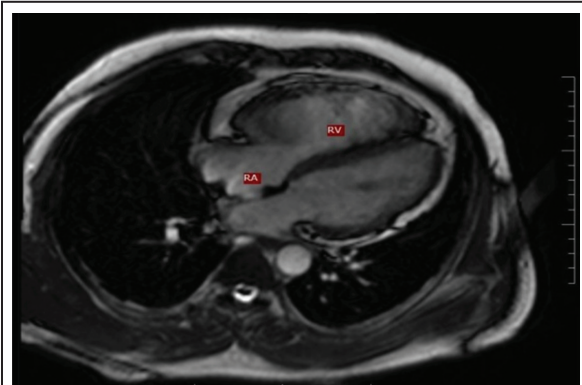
MRI 4 chamber showing dilated RV.
